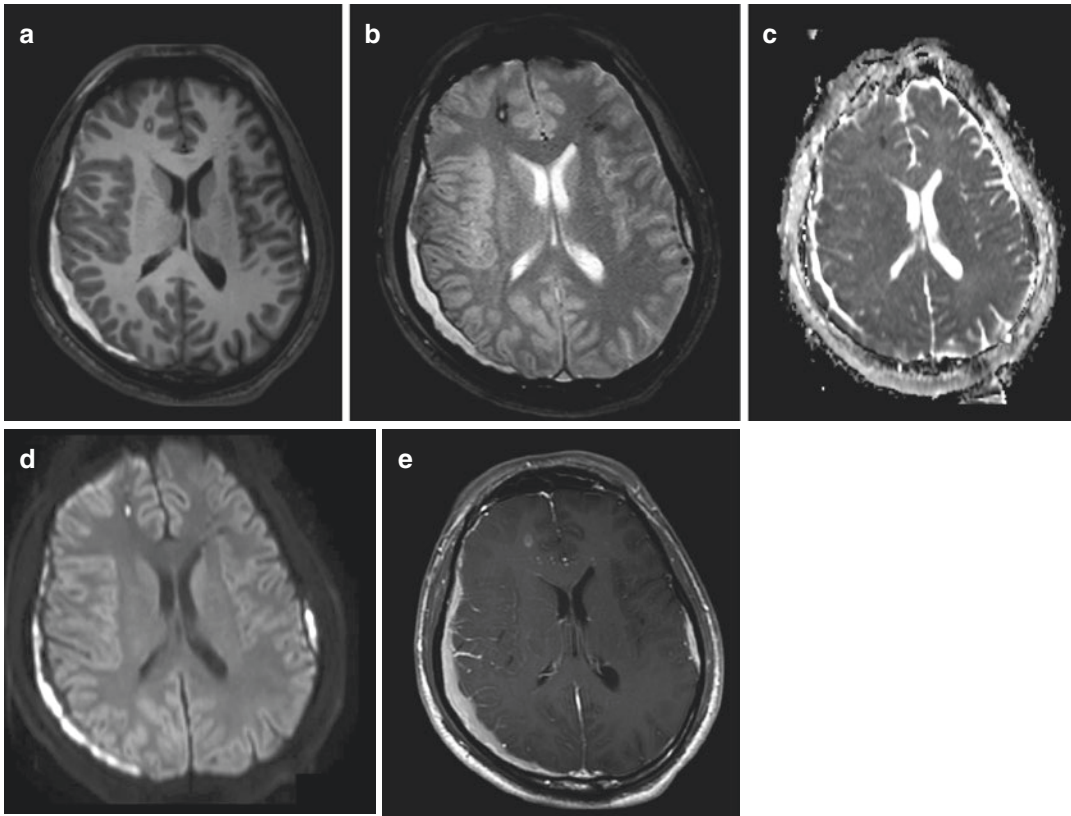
(a–e) MR brain of 22-year-old male with MVC and ejection shows bilateral subacute SDH which are hyperintense on precontrast T1 (a) and show RD on DWI (d) and ADC (c). There is dural and leptomeningeal enhancement on postcontrast T1 (e) on the surface of brain on the right side near the larger SDH due to vascular
